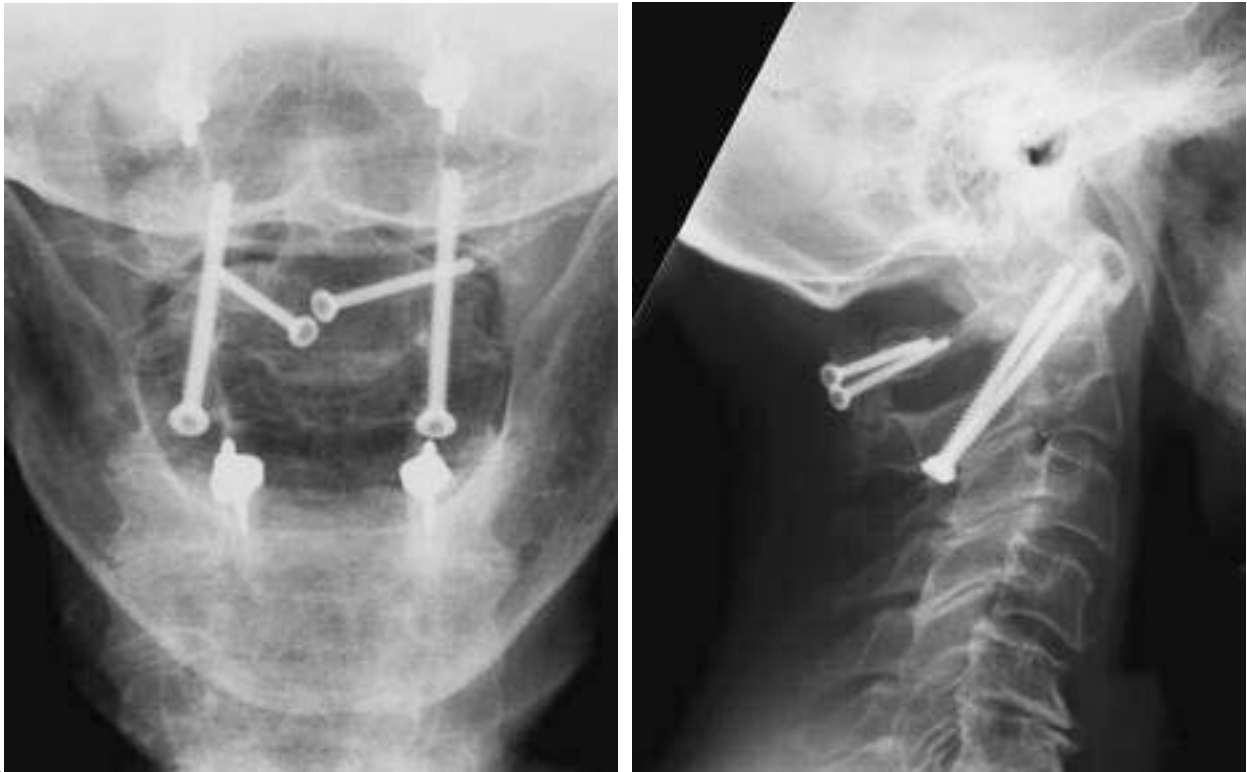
(A) and (B) Anteroposterior and lateral post-op x-rays of a patient presenting with C1/C2 instability caused by rheumatoid arthritis. Owing to the presence of spina bifida in the atlas, the graft placed in the midline was used in the same procedure to reconstruct and fuse the arch of the atlas.
